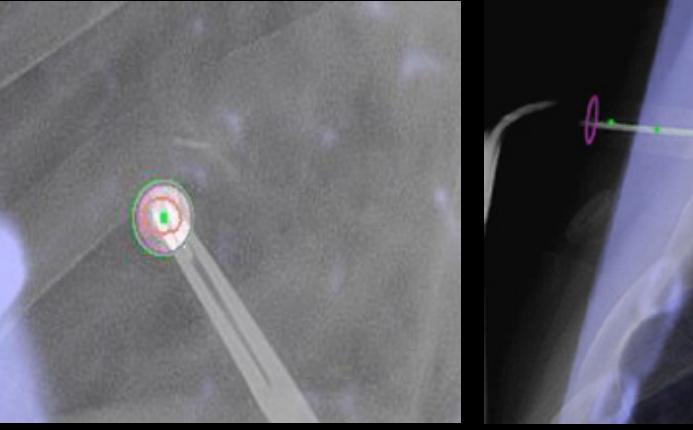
Fiducial marker placement. 2D live fluoroscopic overlay with 3D needle path and cone beam CT volume showing Entry Point view (middle) used to align the needle and the target nodule, and Progress view (right) used to advance the needle towards the target nodule. The fiducial markers are visible on fluoroscopy and positioned beyond the nodule.
